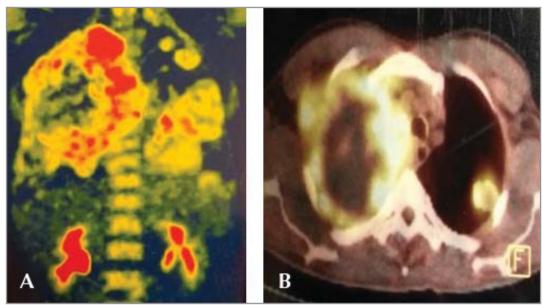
(A,B) Pathologic 18 FDG uptake at mass lesions in both hemithorax and mediastinal lymph nodes at PET-CT.
